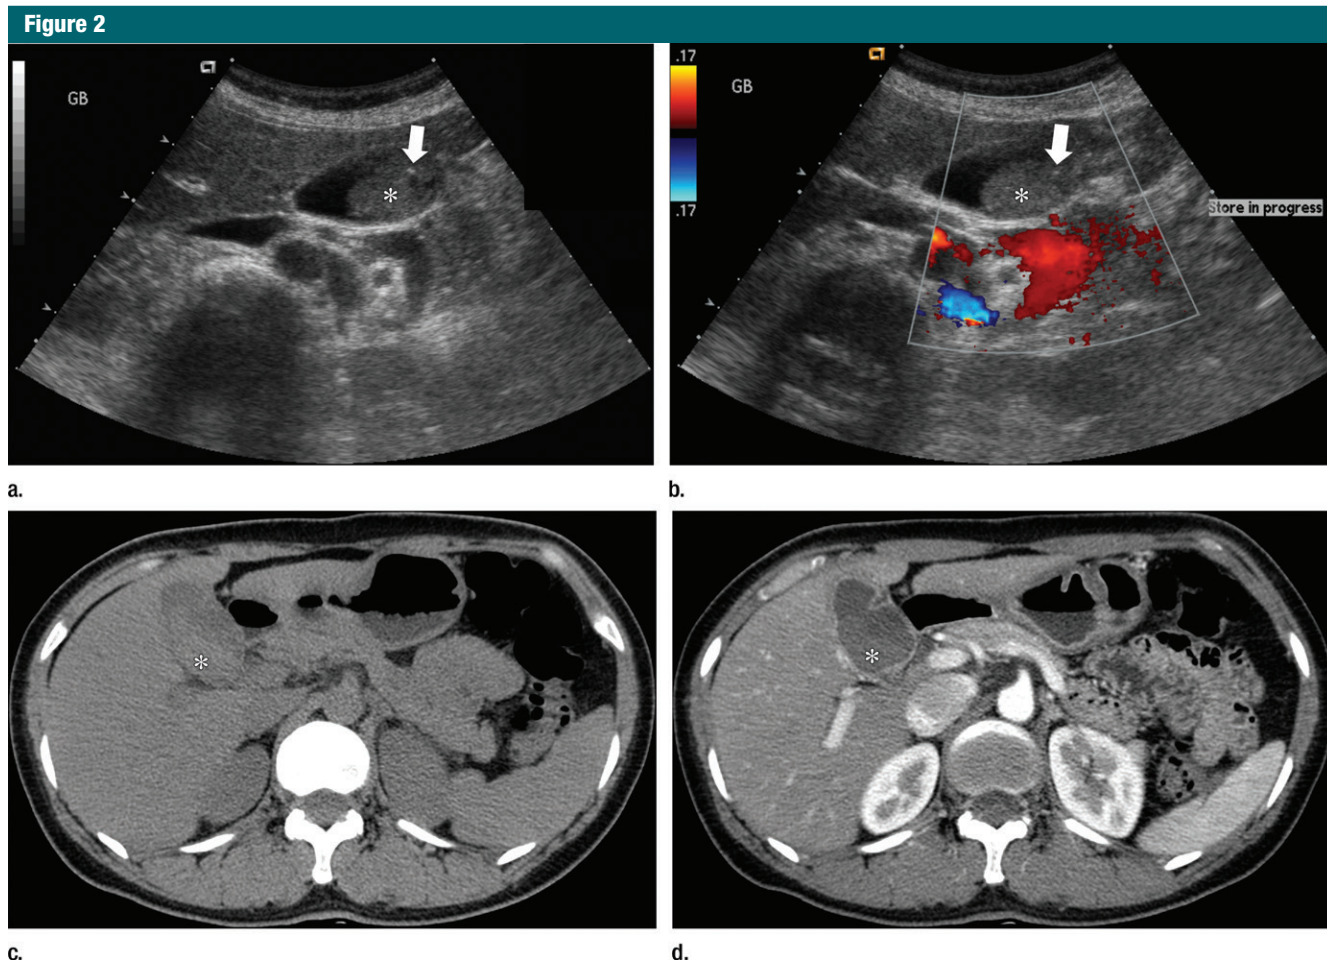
Images in a 58-year-old man with benign tumefactive sludge. (a) On B-mode US image, 2.3-cm echogenic mass without movability is located in body of gallbladder (*). Arrow indicates hyperechoic spot in tumefactive sludge. (b) On color Doppler US image, lesion (*) does not have internal vascularity. (c) Unenhanced axial CT image shows hyperintense lesion in gallbladder (*) compared with adjacent liver. (d) After administration of contrast material, axial CT image shows absence of enhancement of corresponding lesion (*). It was confirmed as sludge with chronic cholecystitis at laparoscopic cholecystectomy.
